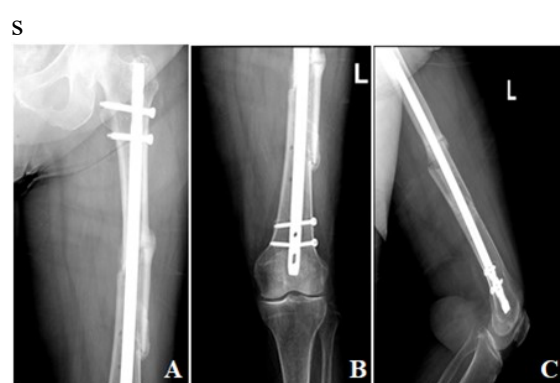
Radiographs of the left femur in the (A, B) Antero-posterior and (C) lateral views done 3 months post operatively showing the intramedullary nail in place stabilizing a healing fracture. A callus is noted with adequate alignment.
